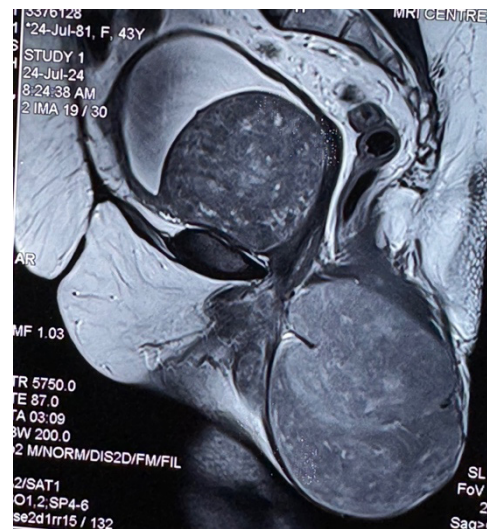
MRI Pelvis showing space of Retzius mass (urethral leiomyoma) – red arrow and large vulvar leiomyoma – yellow arrow
